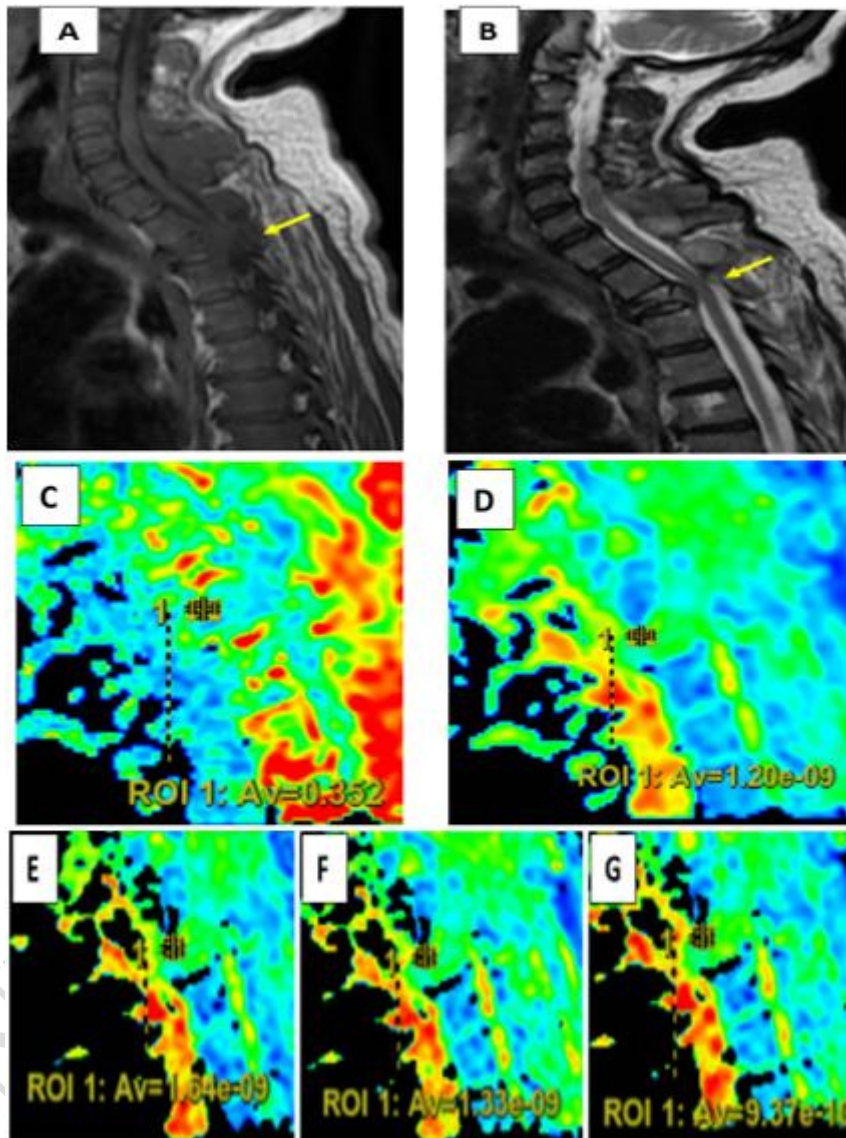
(A-G images): A 60-year-old male patient, he has a history of lung cancer. (A) Sagittal T1-weighted MR image and (B) Sagittal T2-weighted MR image acquired at 1.5 T show collapse and low signal intensity of D3 vertebral body (yellow arrows) with retro-pulsed fragment compressing the thecal sac, (C) Sagittal color coded FA map image shows decreased FA value at the level of vertebral fracture (0.352), (D) Sagittal color coded ADC map image shows increased ADC value at the level of vertebral fracture (1.20), and (E, F& G) Sagittal color coded diffusion coefficient images at
